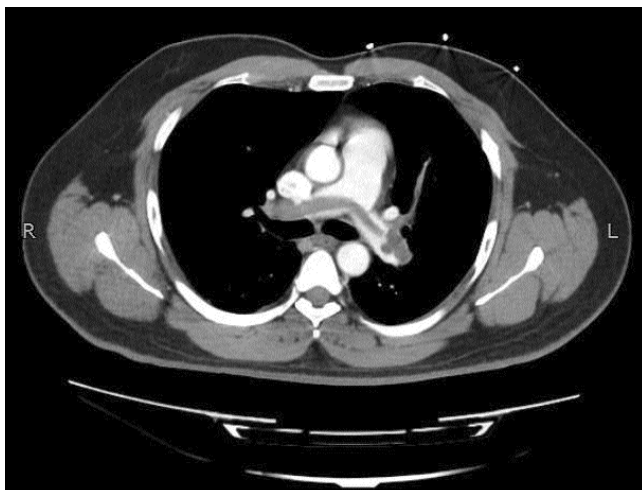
CT chest axial view showing filling defect in bilateral pulmonary arteries "saddle embolism".
